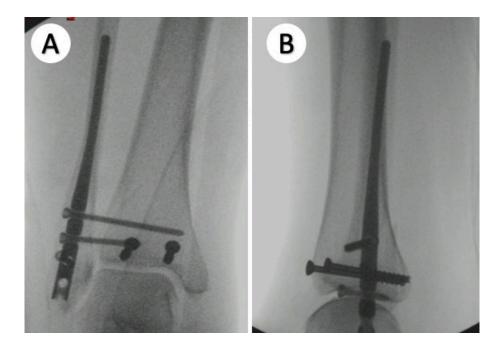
Anteroposterior (A) and lateral (B) radiographs demonstrating the final surgical construct.
